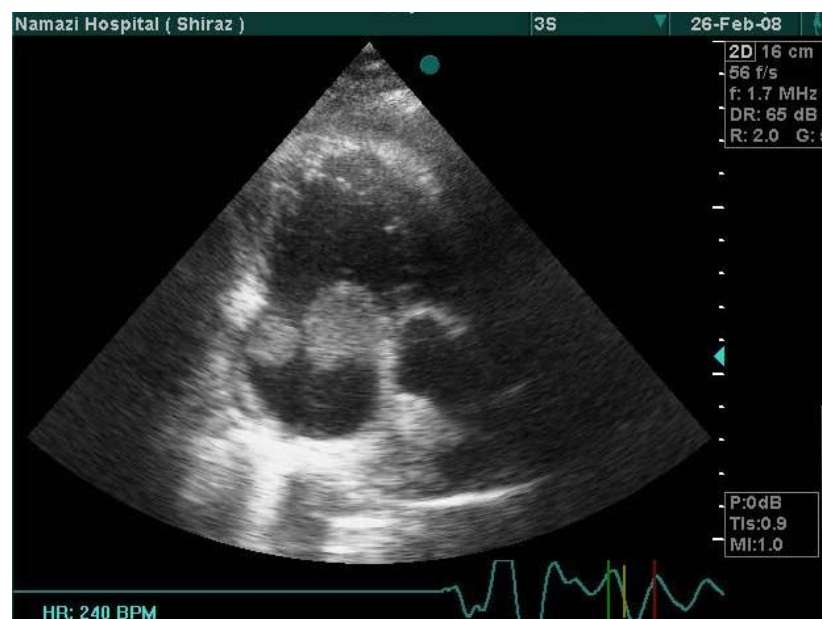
Two large thromboses in right atrium in four chamber view of echocardiography
